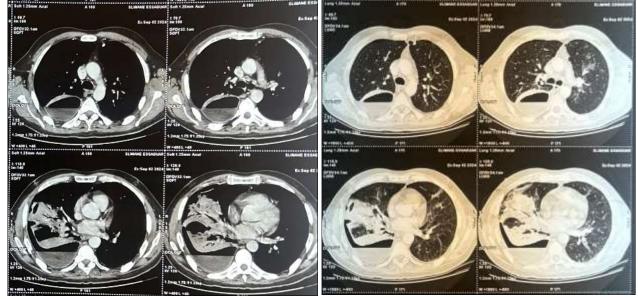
Thoracic CT showing a right basal pulmonary abscess ruptured into the pleural space and complicated by pyopneumothorax.
